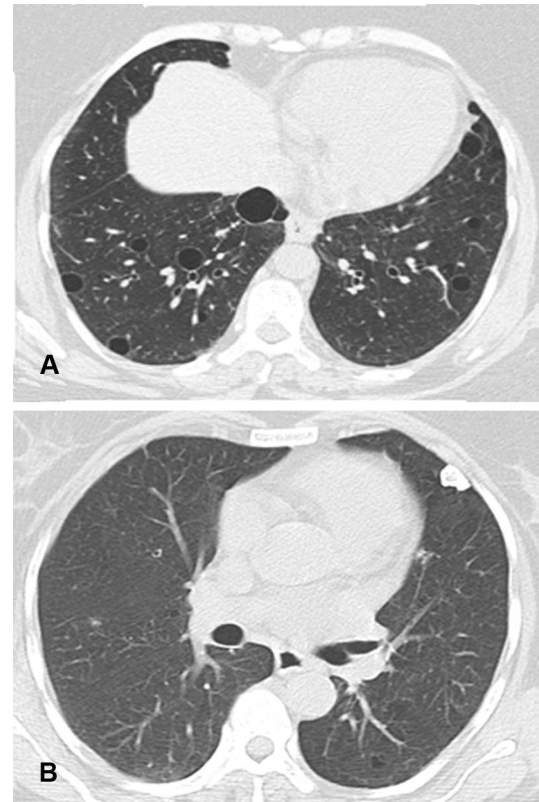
A 53-year-old woman with lymphocytic interstitial pneumonia. Axial CT images with lung window settings at different levels (a–b) show multiple cyst lesions and some parenchymal nodules. Note in (b) a peripheral calcified nodule in the left lung. Biopsy confirmed the diagnosis of associated amyloidosis
